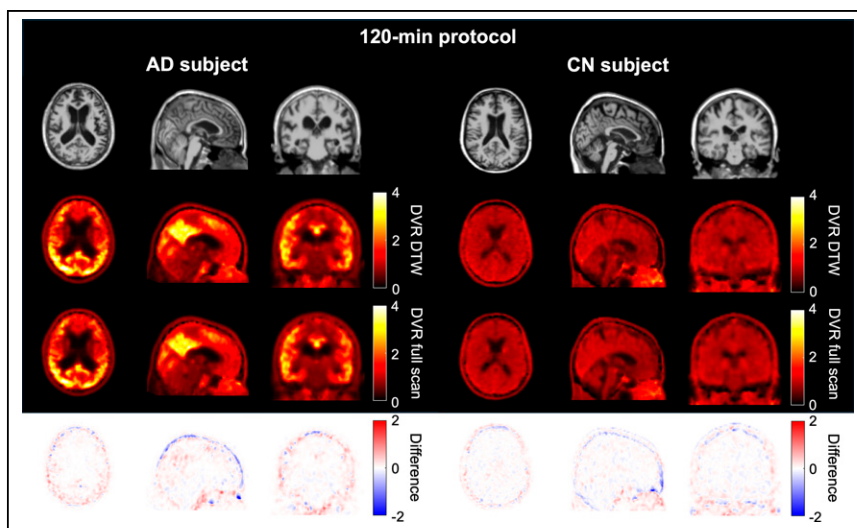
DVR maps computed for 60-min break with biexponential fit and 120-min scan analysis, and corresponding MR structural images in AD subject and CN subject. First row shows magnetization-prepared rapid gradient echo MRI for anatomic reference. Second row shows parametric DVR images generated from DTW images. Third row shows parametric DVR images generated from full 120-min dynamic images for comparison. Fourth row shows images of difference (DVR DTW – DVR full scan).
